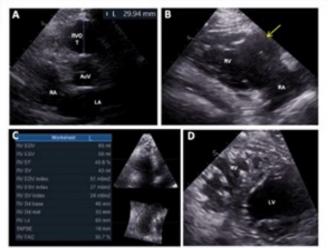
f-Transitionacic echocardiogram study. A - RVOT measurement from the parasternal short-axis view; 8 - modified RV view with subvaluate aneurysm (jetliow arrow); C - RV measurements; D - Trabeculation of RV in a parasternal short-axis view. AvV = aortic valve; LA = left strium; LV = left ventride; RA = right atrium; RV = right ventricle; RVOT = right ventricular outflow tract.
